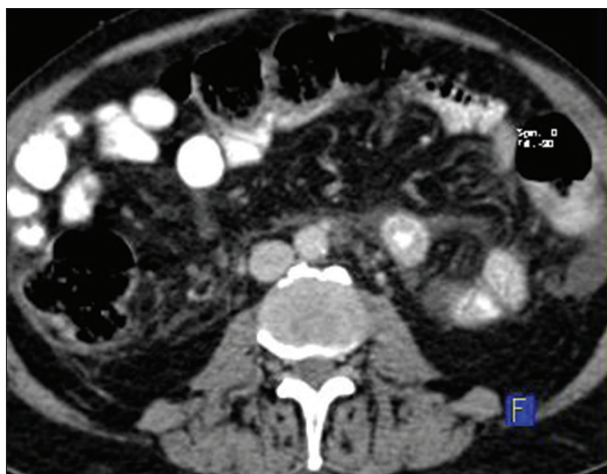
Computed tomography scan images of fluorodeoxyglucose positron emission tomography–contrast-enhanced computed tomography show congestion in small bowel mesentery and greater omentum suggestive of features of mesenteric ischemia as complication of portal vein tumor thrombosis
